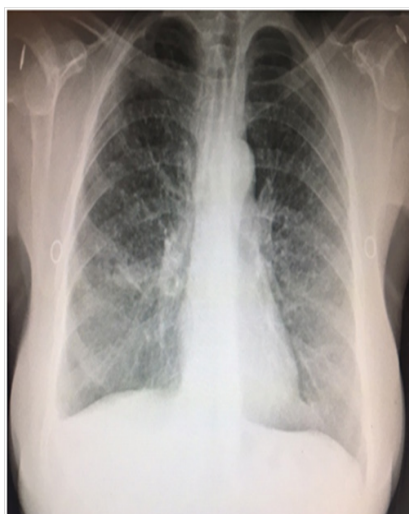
Chest x-ray showing diffuse miliary nodules and right pleural effusion.
